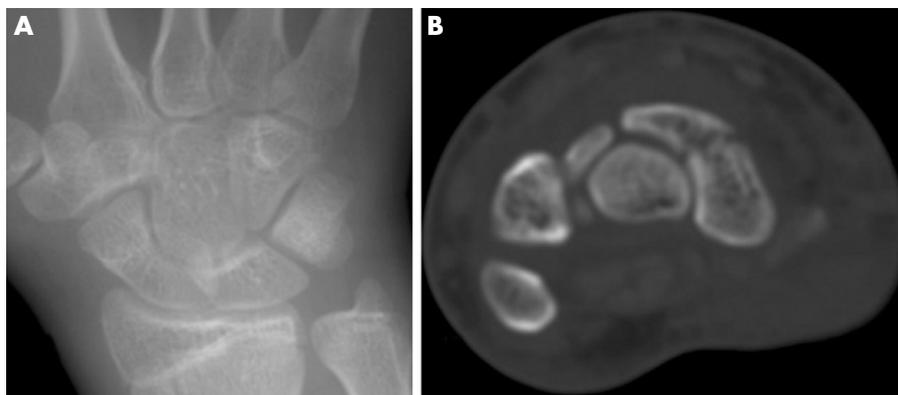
A 20-year-old man with an injury from a fist blow. (A) Posteroanterior view of the wrist shows no fracture line. (B) Axial CT image showing scaphoid fracture.
